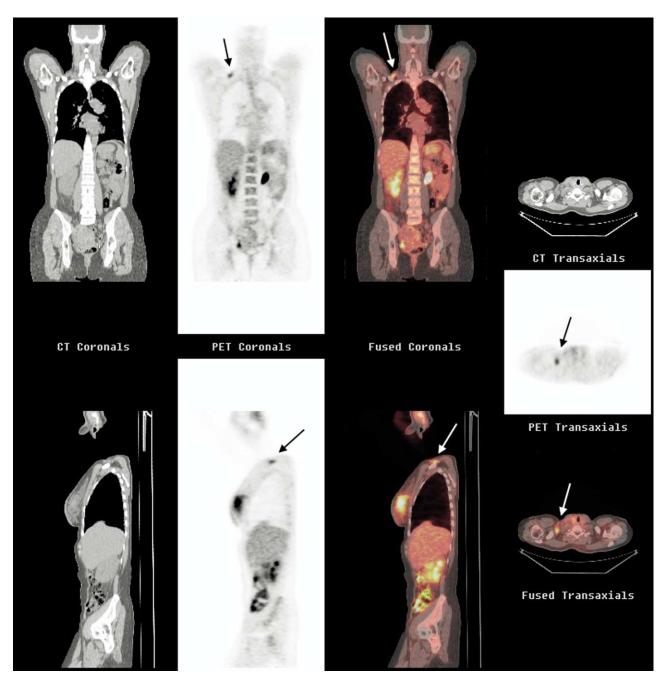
Supraclavicular but no axillary node on FDG-PET/computed tomography (CT). CT, FDG-PET, and FDG-PET/CT images (left to right) from an FDG-PET/CT scan of a patient with invasive ductal cancer in the right breast measuring 5 cm. Note there is abnormal FDG uptake in a right supraclavicular node (arrows on the FDG-only and FDG-PET/CT registered images), but none in the axilla. (Color version of figure is available online.)
